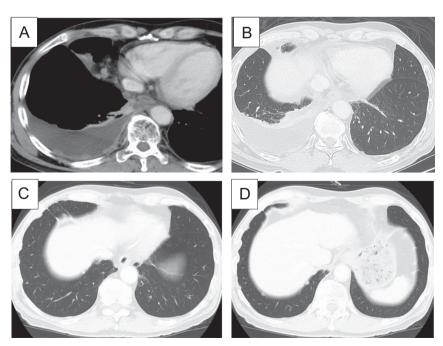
A, B: Chest computed tomography (CT) scan demonstrating right pleural effusion and multiple pleural disseminations without any findings of interstitial pneumonia. C, D: Chest CT scan demonstrating multiple right pleural disseminations and no findings of interstitial pneumonia, before the appearance of right pleural effusion.
